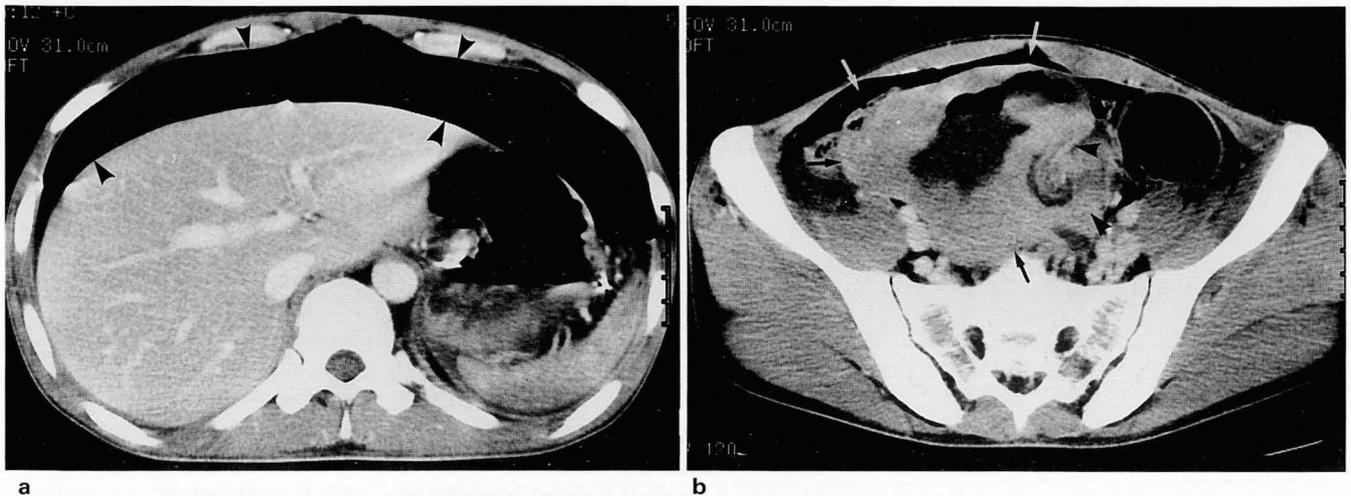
a. Contrast enhanced CT scan of upper abdomen shows massive pneumoperitoneum (arrowheads).
